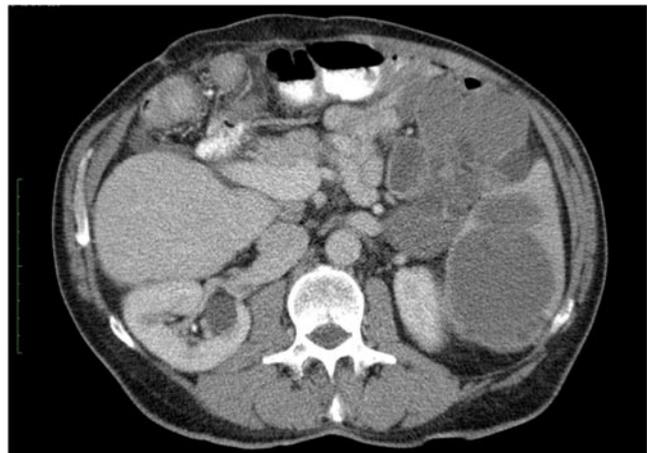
Axial contrast enhanced CT of the upper abdomen at the level of the right kidney.
